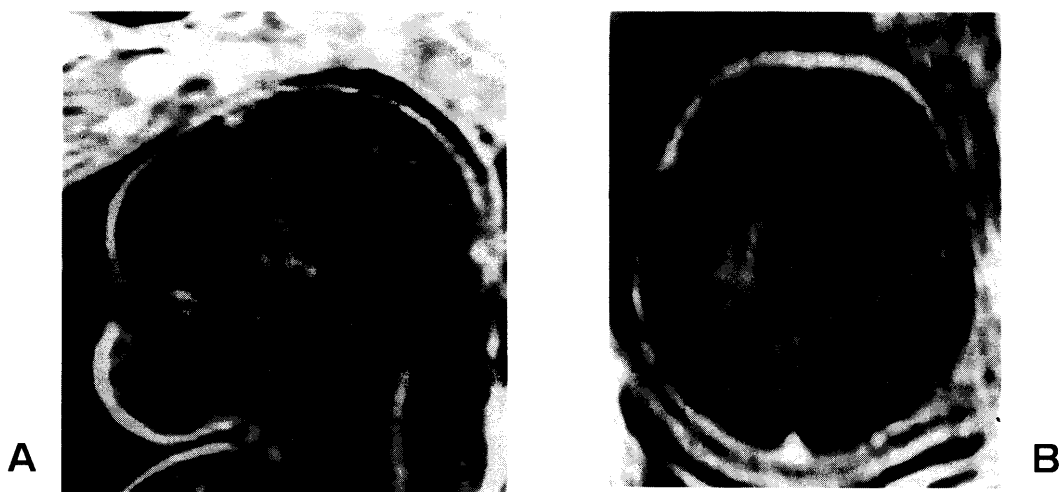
T1 weighted image (TR 50msec, TE 4.1msec) of 1.5 Tesla MRI on 34 weeks of gestation. A, Sagittal images. Cystic dilatation of the fourth ventricle, dysgenesis of the cerebellar vermis and elevation of the tentorium were noted. B, Axial images. No enlargement of lateral ventricles were noted.
